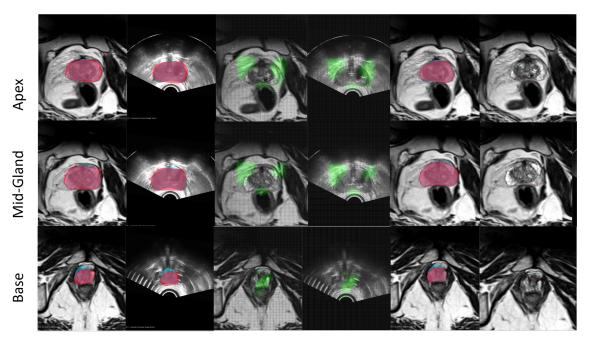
Sample MRI-TRUS registration results for a patient using 3D segmented surfaces as landmark and B-spline grid to warp the MRI on the targeted TRUS. The blue segmented area represents the prostate surface on TRUS image and the red area annotates the prostate gland on MRI.
